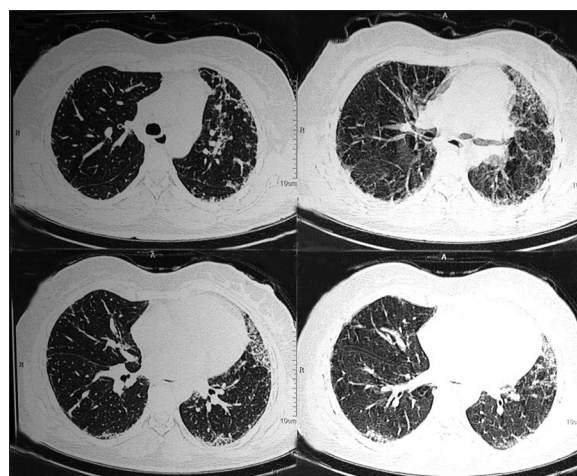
High-resolution CT scan showing lung fibrosis
